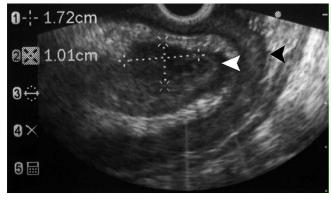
Endoscopic ultrasound image of sigmoid intussusception (black arrow) with adenocarcinoma at the apex of the intussusception acting as the lead point (white arrow).
